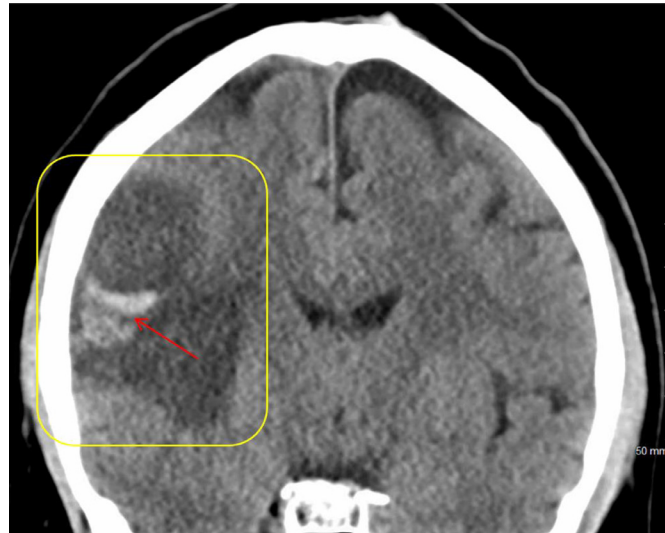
CT brain with contrast (coronal view) demonstrating a large area of decreased attenuation (yellow box) involving much of the distribution of the right middle cerebral artery consistent with an acute infarct with areas of acute hemorrhage (red arrow) throughout this infarct.
